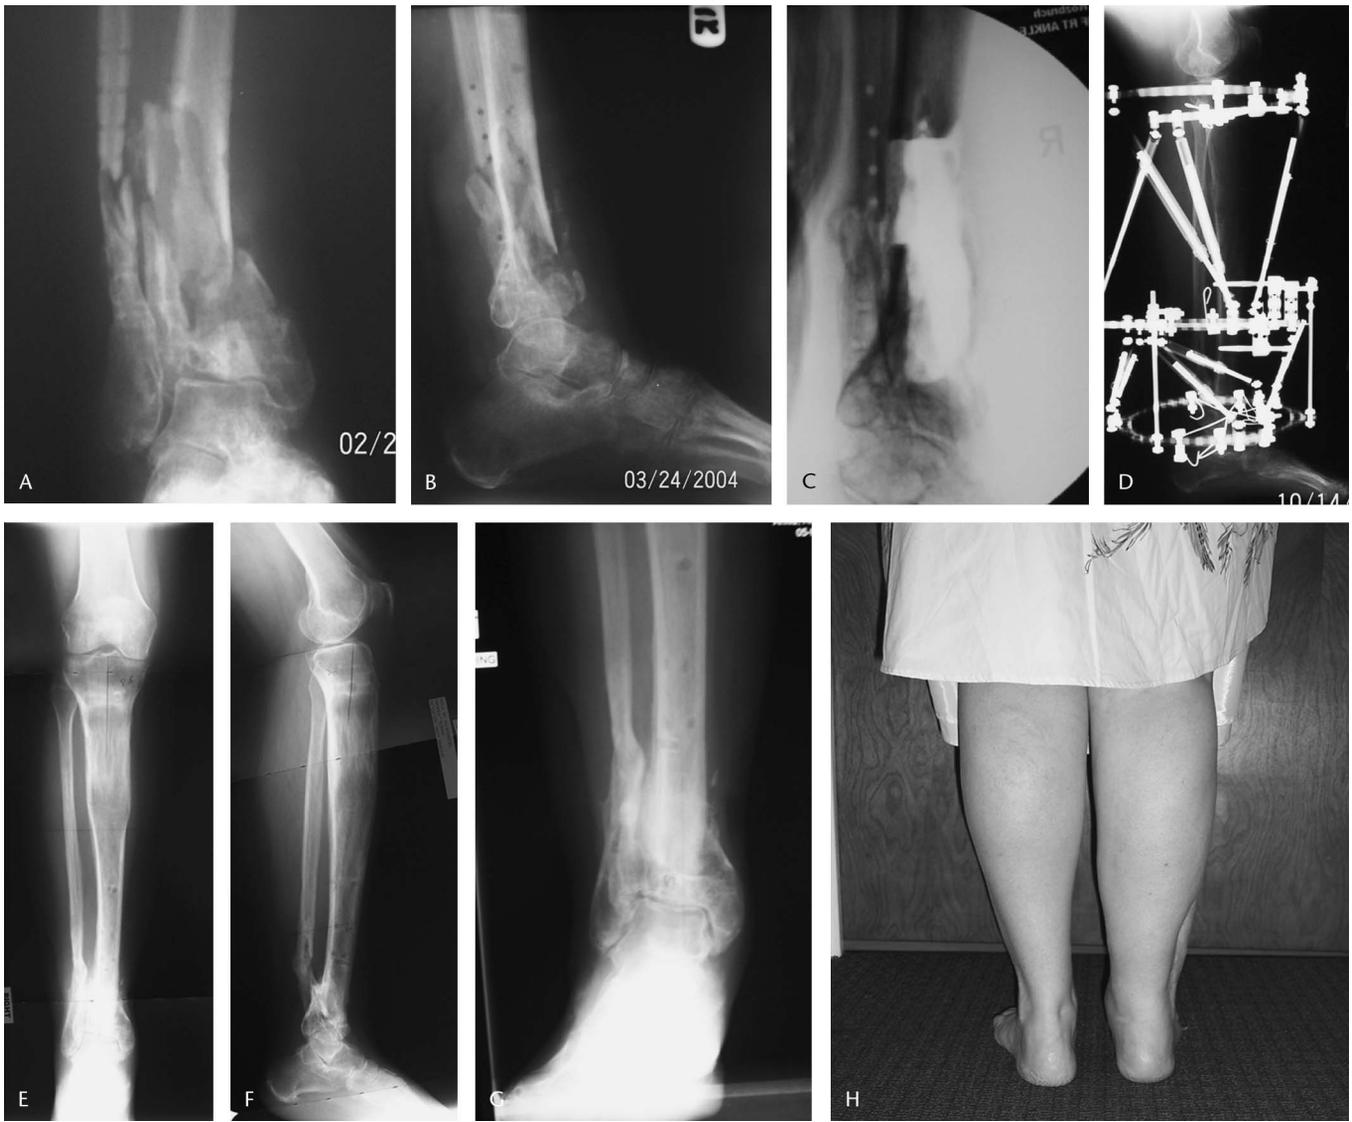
A, B, Preoperative AP and lateral radiograph of an infected distal tibia nonunion. C, Intraoperative lateral radiograph after 9-cm excision of necrotic bone. The ankle was preserved with a small segment of distal tibia. D, Lateral radiographs of the mounted TSF showing the proximal tibia lengthening site and the distal tibia docking site at the end of distraction. The TSF was set up to lengthen proximally and compress distally. E, F, AP and lateral radiograph showing the healed proximal tibia lengthening and the distal tibia nonunion (1 year after frame removal). G, AP radiograph showing the healed distal tibia nonunion with preservation of the ankle joint (1 year after frame removal). H, Back view of the patient (1 year after frame removal).
